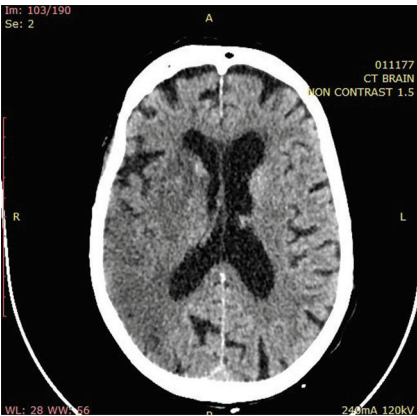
Non-contrast follow-up CT after 24-hour demonstrating large ischemic infarction in the right MCA territory
